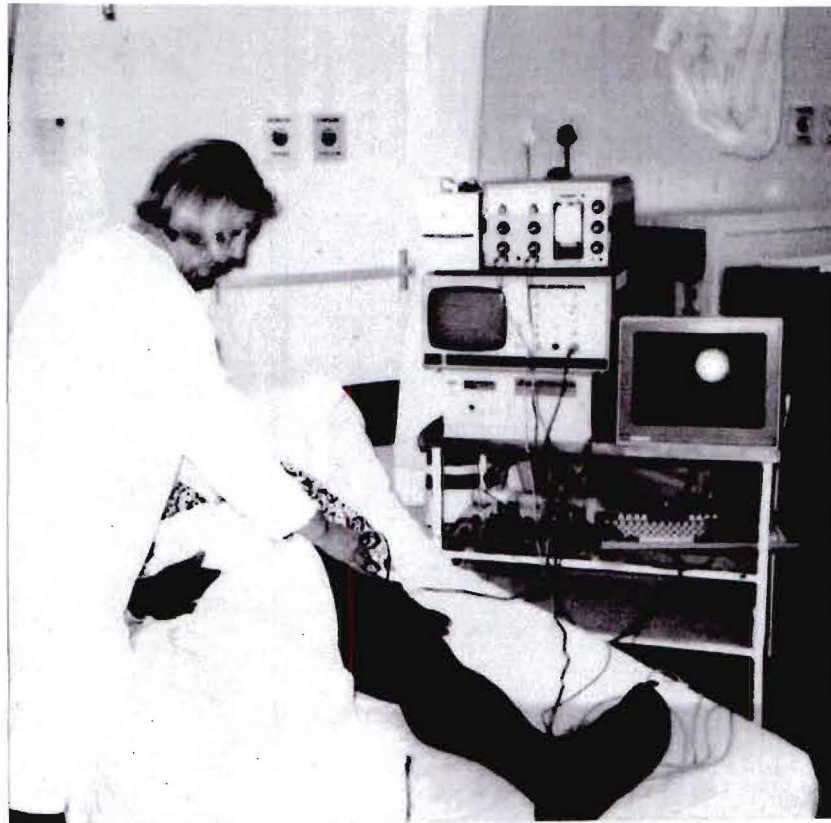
Clinical pseudo-synchronous measurement of the External Iliac Doppler Blood Velocity Waveform using the prototype Haemodynamic Data Acquisition System
